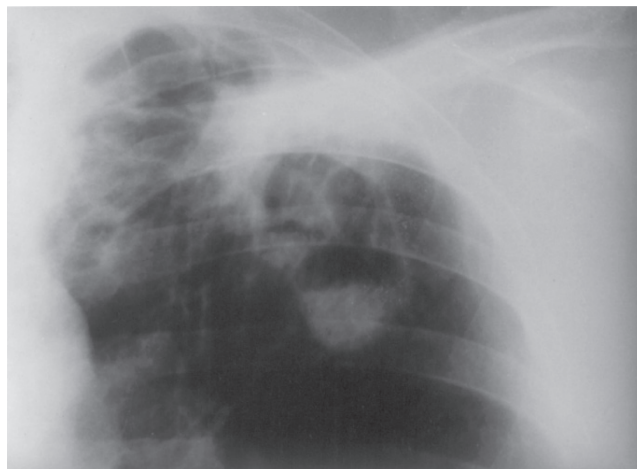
Case 3 - A chest roentgenogram shows partial fibroatelectasic retraction of the left upper lobe and a rounded opacity within the dependent portion of a thin-walled cavity.
